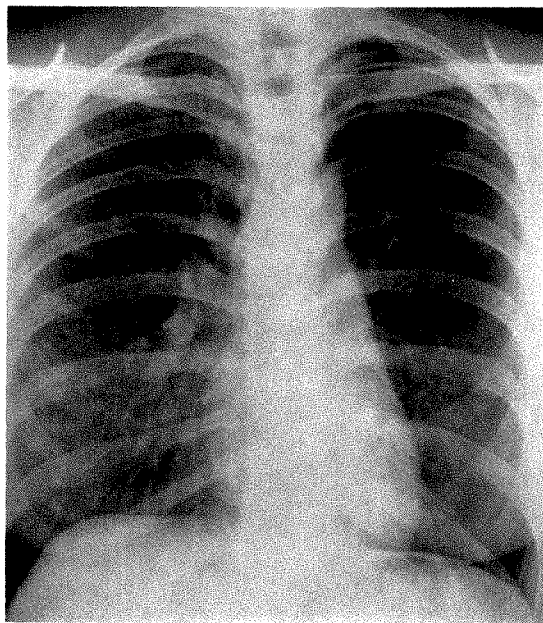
Routine chest roentgenogram taken during inspiration reveals increased radiolucency of the entire left lung, apparently due to a decrease of vascular shadows, with no evidence of overexpansion.
